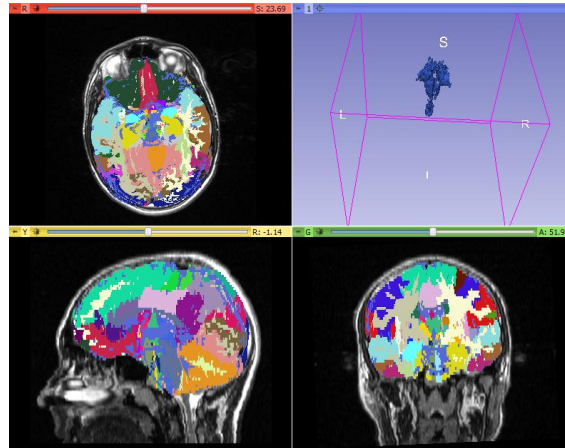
Segmentation of normal brain MR image data.
